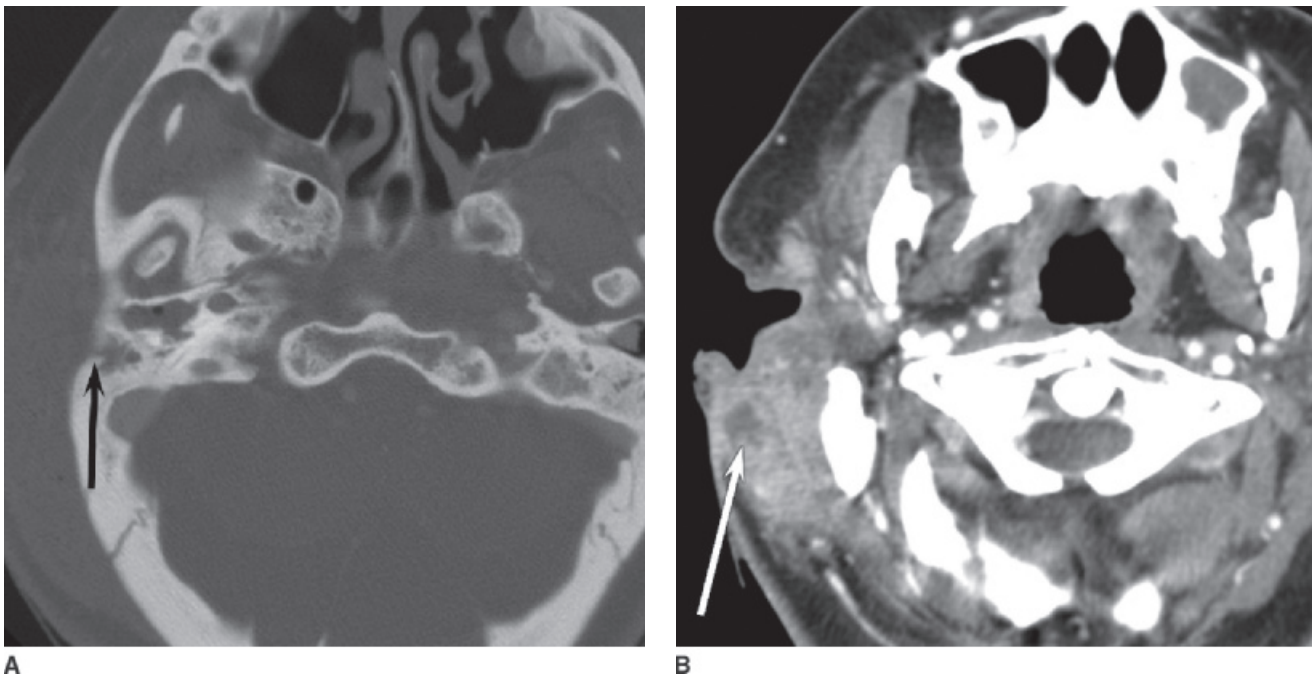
Coalescent mastoiditis with Bezold abscess. A: Axial contrast-enhanced CT on bone window shows complete opacification of underpneumatized right mastoid air cells with a lateral cortical breakthrough (arrow). The external auditory canal is also nearly completely opacified. B: More inferior image, on soft tissue windows, shows abscess (arrow) alongside the mastoid tip, involving the SCM (Bezold abscess).
